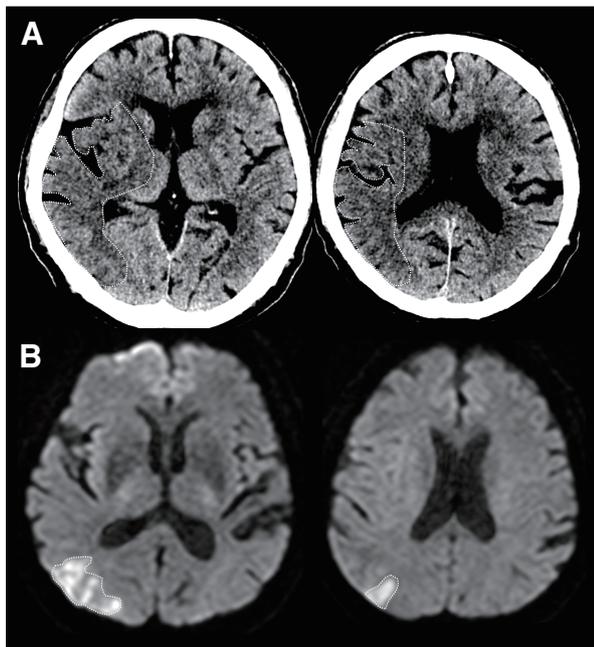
Non-contrast CT 7 hours after onset shows early ischemic changes in the right L, I, IC, M2, M3, M5, and M6 regions (CT-ASPECTS, 3) (A). DWI 7.5 hours after onset shows hyperintense lesions in the M3 and M6 regions (DWI-ASPECTS, 8) (B). ROIs for hypoattenuation and DWI hyperintensity are placed manually on CT and DWI (in dashed lines). Therefore, the patient has RD in the right L, I, IC, L, M2, and M5. ASPECTS: acute stroke prognosis early CT score; DWI: diffusion-weighted imaging; RD: reversed discrepancy; ROIs: regions of interest
